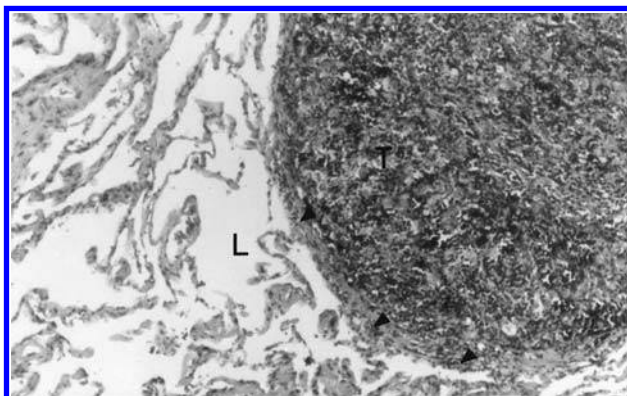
Thymoma. (a) Well-encapsulated small thymoma noted on chest CT. (b) Large invasive thymoma with aortic involvement. Note the lack of a fat plane between the mass and the vascular structures. (c) Thymoma invading tumor capsule. Arrow = thymoma; arrowhead = capsular invasion; T = thymoma; L = adjacent normal lung; A = aorta.
